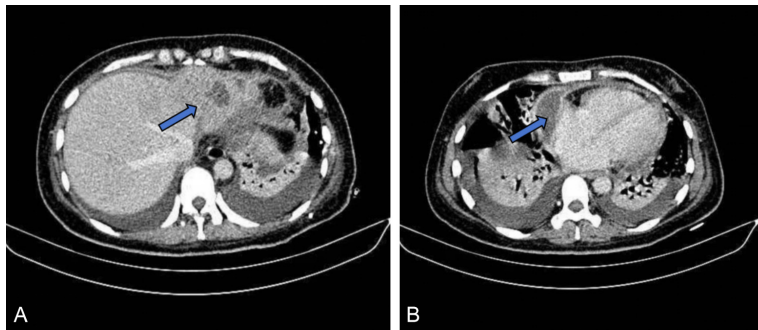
Follow-up contrast-enhanced CT images after treatment. A. Axial CT scan demonstrating a significant reduction in the size of the hepatic abscess (blue arrow) compared with the previous scan. B. Axial CT scan showing a marked reduction in pericardial effusion (blue arrow) compared to the previous examination.
